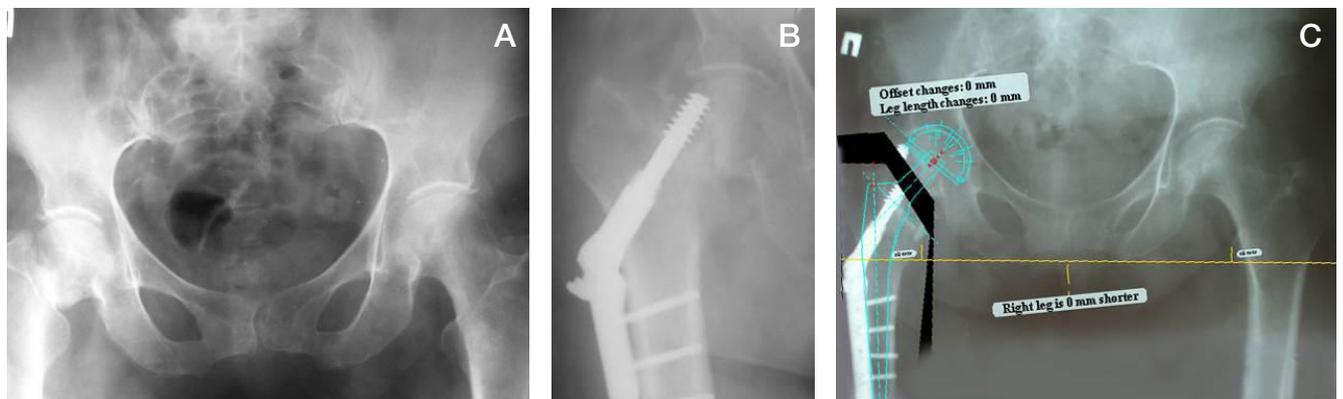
Survey frontal x-ray image of the pelvis and the right hip joint of the 73-year-old patient. Diagnosis: condition after osteosynthesis involving the use of the DHS system. False joint of the right femoral neck. A. X-ray image acquired at admission to surgery — osteosynthesis of the right femur involving the use of the DHS system. B. X-ray image acquired after osteosynthesis involving the use of the DHS system. C. Sizing and positioning of the endoprosthesis components using the TraumaCad v. 2.4 software. (Planned size of the acetabular component — 50, femoral component — 4)
